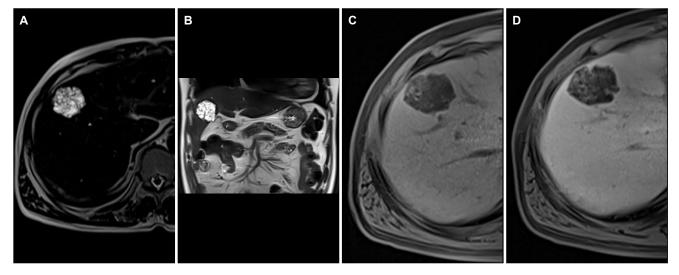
A 63-year-old man with biliary adenofibroma (case 1). (A) Axial and (B) coronal T2-weighted images showed a bright signal intensity tumor with hypointense septa. (C) Axial unenhanced T1-weighted image showed a low signal intensity tumor with a lobulated border. After gadolinium administration, (D) axial delayed phase T1-weighted image showed septal enhancement.
